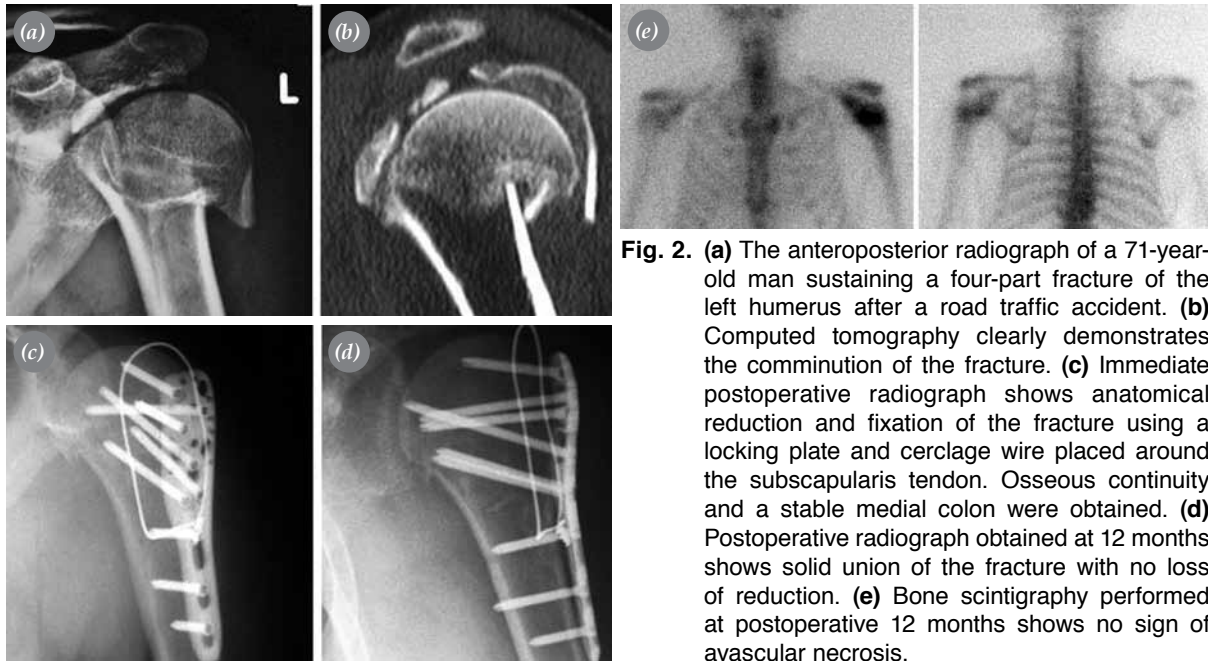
(a) The anteroposterior radiograph of a 71-year-old man sustaining a four-part fracture of the left humerus after a road traffic accident. (b) Computed tomography clearly demonstrates the comminution of the fracture. (c) Immediate postoperative radiograph shows anatomical reduction and fixation of the fracture using a locking plate and cerclage wire placed around the subscapularis tendon. Osseous continuity and a stable medial column were obtained. (d) Postoperative radiograph obtained at 12 months shows solid union of the fracture with no loss of reduction. (e) Bone scintigraphy performed at postoperative 12 months shows no sign of avascular necrosis.
